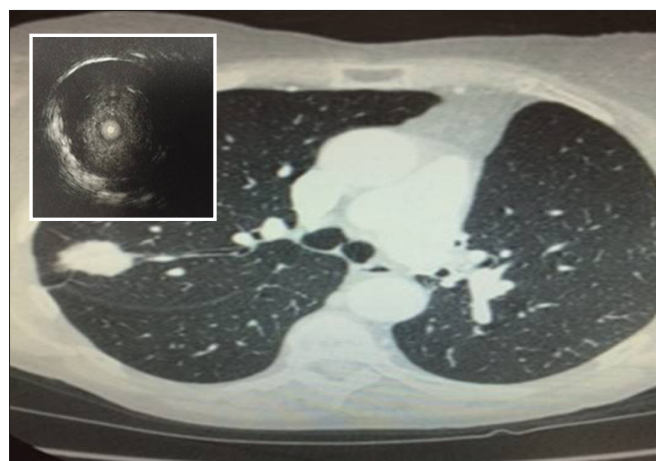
CT scan and radial endobronchial ultrasound image of patient with a peripherally situated lung adenocarcinoma
